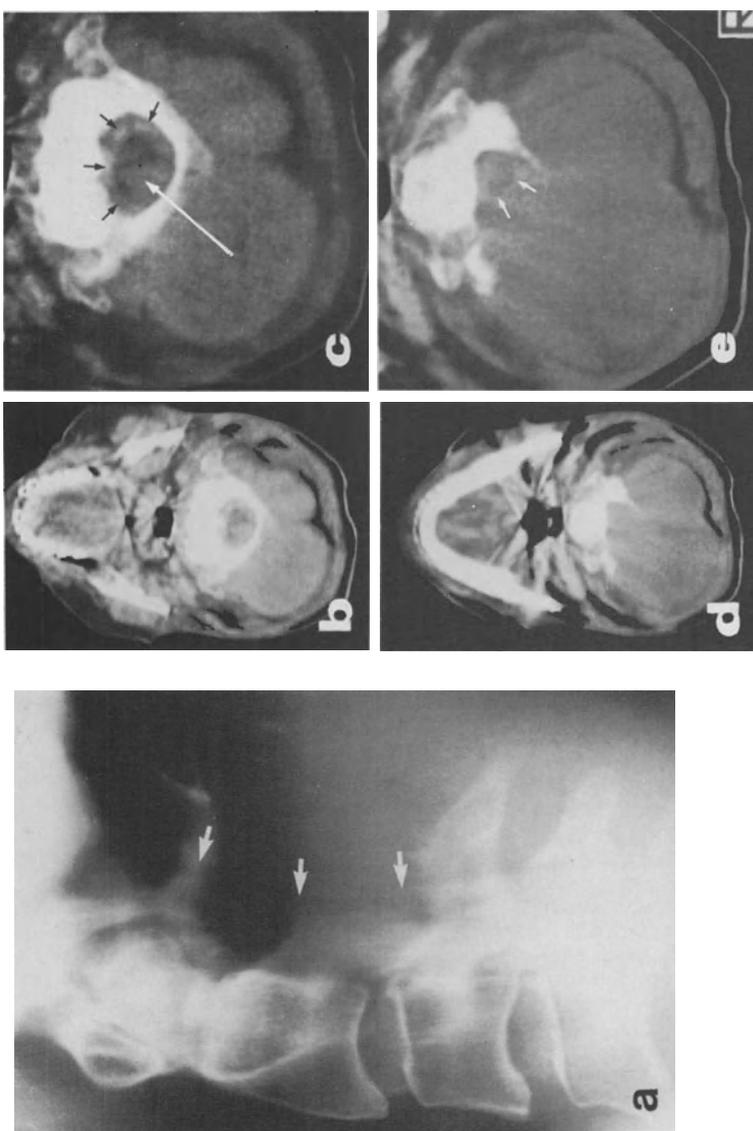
a-e. Extradural, intravertebral and paravertebral tumor location: High cervical metastasis of an undifferentiated carcinoma. a Midline metrizamide myelotomogram showing marked compression of dural sac at level of C 1 and C 2 (*arrows*); extensive destruction of neural arch of axis. b, c CT scan at level of C 1 after intravenous bolus enhancement (full picture and quadrant enlargement) showing a mass encircling (c, *small black arrows*) and compressing dural sac from left (c, *long white arrow*); tumor invasion of posterior arch of atlas, extensive involvement of paravertebral (neck musculature, particularly on left. d, e Scan at the level of C 2 after intravenous bolus enhancement (full picture and quadrant enlargement) showing marked compression of the dural sac (e, *arrows*), destruction of the neural arch of the axis and very extensive paravertebral soft tissue infiltration with central necrosis
